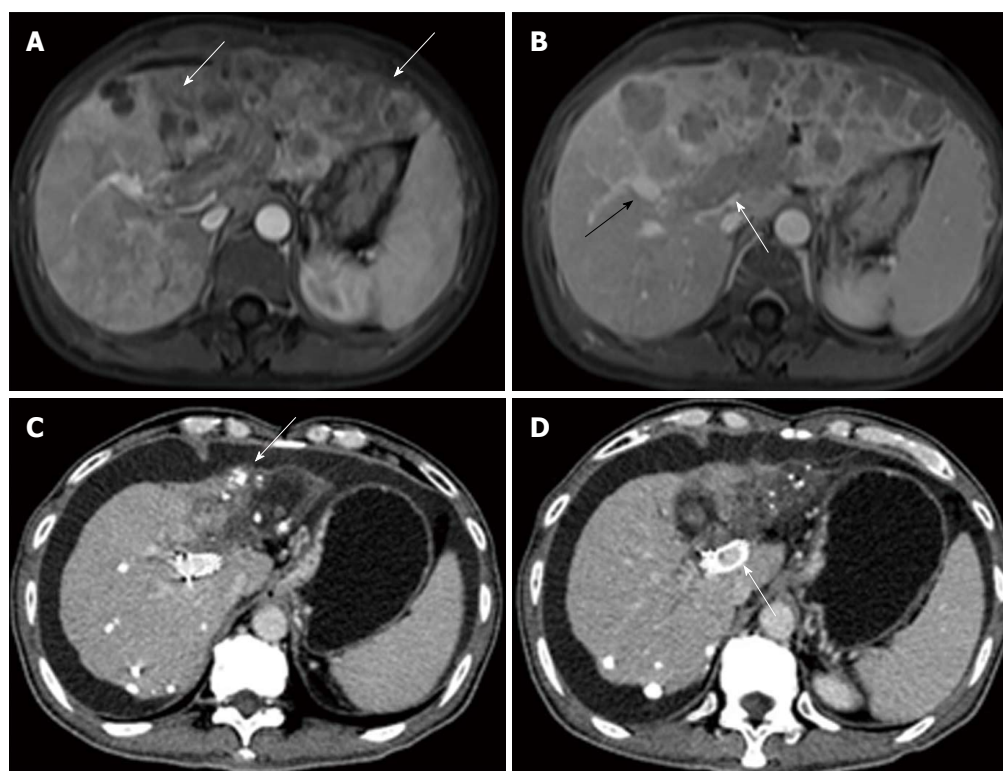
Images from a 50-year-old man who had hepatocellular carcinoma with main portal vein tumor thrombus. A: Contrast-enhanced abdominal magnetic resonance imaging before therapy. Diffuse hepatocellular carcinoma (white arrow) was detected in the left lobe. B: The second order of the right portal vein (black arrow) was patent. Tumor thrombus (white arrow) was observed in the left portal vein, the first order of the right portal vein, and the main portal vein. C: Contrast-enhanced abdominal CT image 24 mo after first therapy. Deposition of iodized oil (white arrow) within tumor was observed and the left lobe was atrophied. D: The stent was still patent (white arrow).
